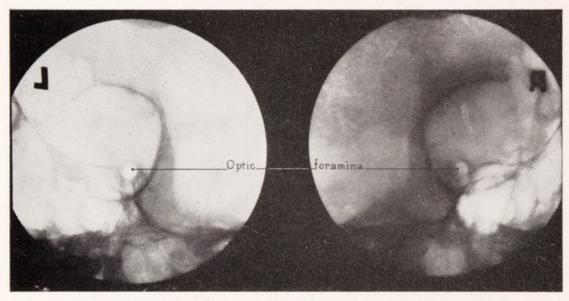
Case 23. X-rays of orbital foramina, showing reduction in size of foramen on tumor side.
